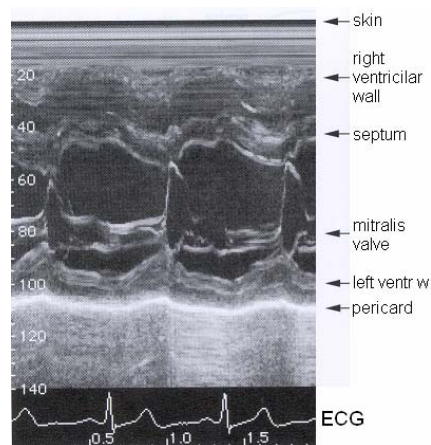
Echocardiogram in M-mode
